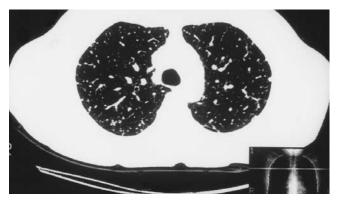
Computed tomographic scan of chest with multiple pulmonary metastases.
